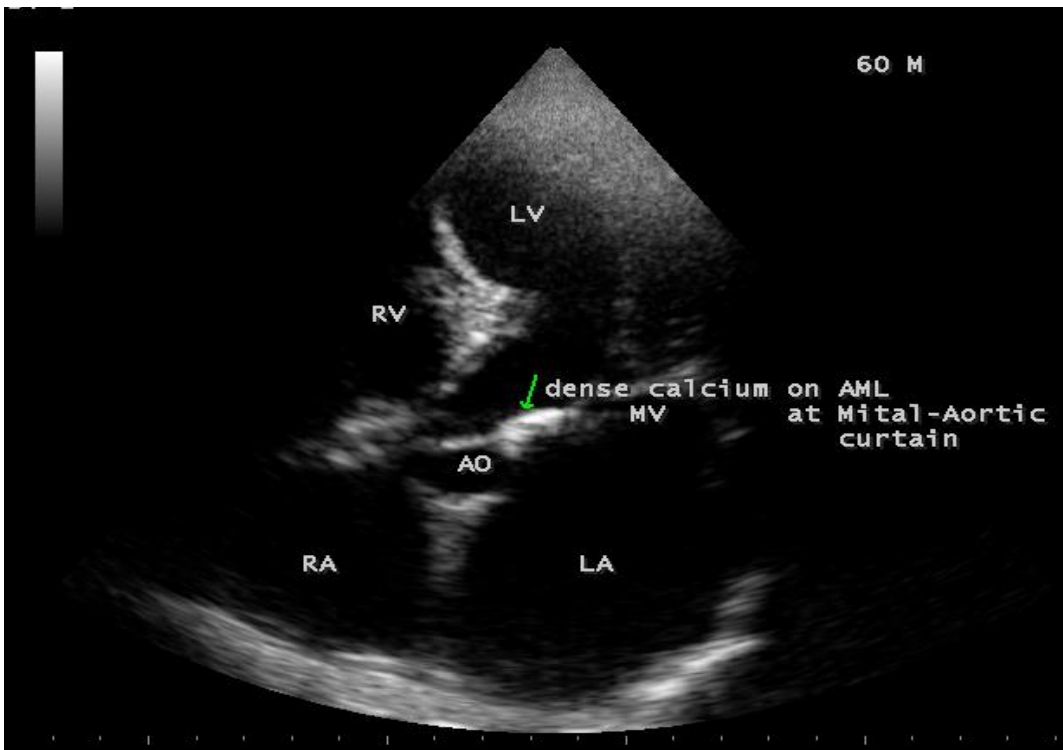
Parasternal long axis view showing the dense calcium in aortic valve and anterior mitral leaflet in EMF (endomyocardial fibrosis) in a 58-year old male.
